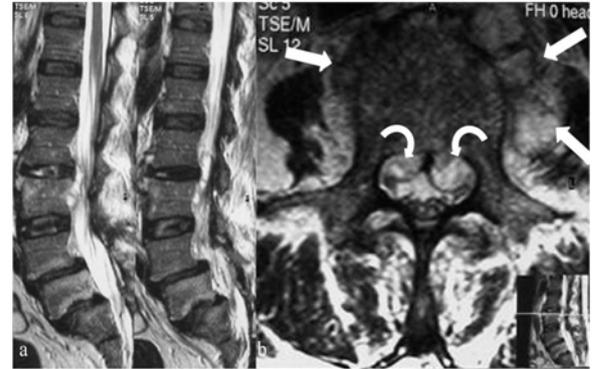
Sagittal T2 weighted image demonstrates brucellar spondylodiscitis at L2-3; increased signal intensity involving L2-3 disc and confluent increased signal intensity involving subchondral parts of L2 and especially L3 vertebrae with paravertebral and epidural abscess. There are also seen severe end plate degenerations and disc degenerations along with grade 1 spondylolisthesis at L4-5 and L5-S1 levels. 2b. T2-weighted axial image reveals central canal narrowing with mild indentation of dural sac and L3 nerve roots by hyperintense bilobulated epidural abscesses (curved arrows). There is a paravertebral abscess especially on the left anterolateral side of the vertebral body (straight arrows).
